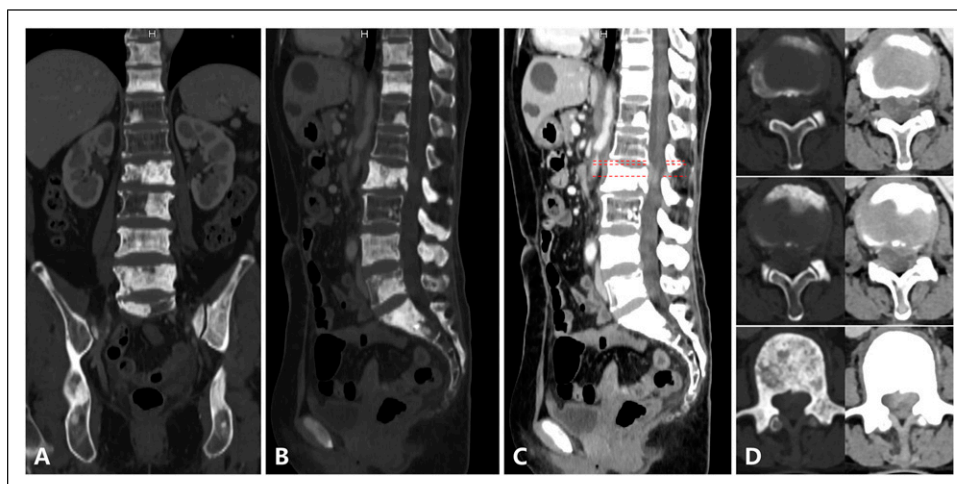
Preoperative coronal reconstructed (A) and sagittal bone window CT (B) show multiple irregular hyperdense lesions in the vertebrae of thoracic, lumbar and sacrococcyx, iliac bone. The sagittal soft-tissue window CT shows the soft tissue density mass in the spinal canal at L2 level (C) and the corresponding axial CT suggests Grade 2-3 epidural spinal cord compression (ESCC) (D).
